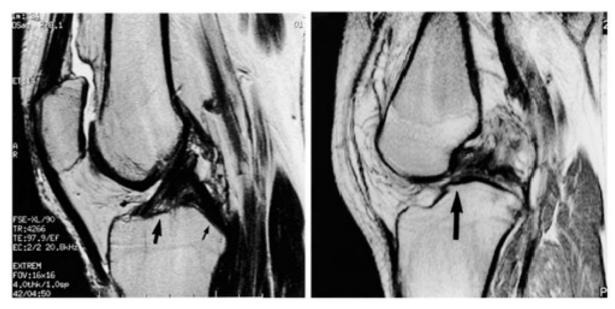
Left: MRI of normal knee with intact anterior cruciate and posterior cruciate ligament Right: MRI of knee with anterior cruciate ligament tear.(13)
